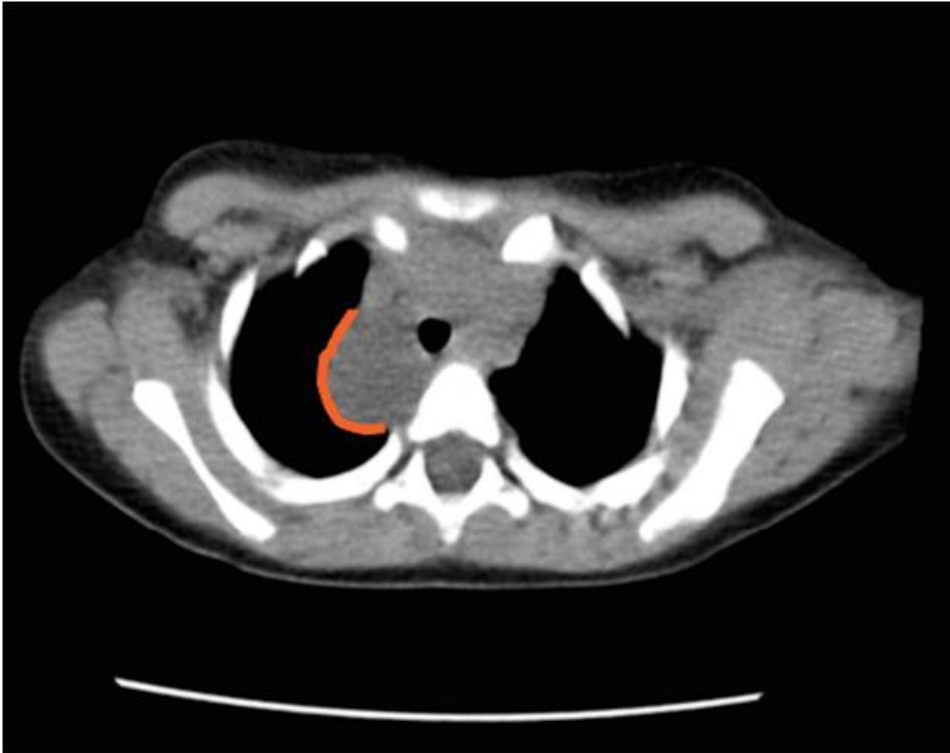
Thoracic CT scan showing a nodular paramediastinic mass.
